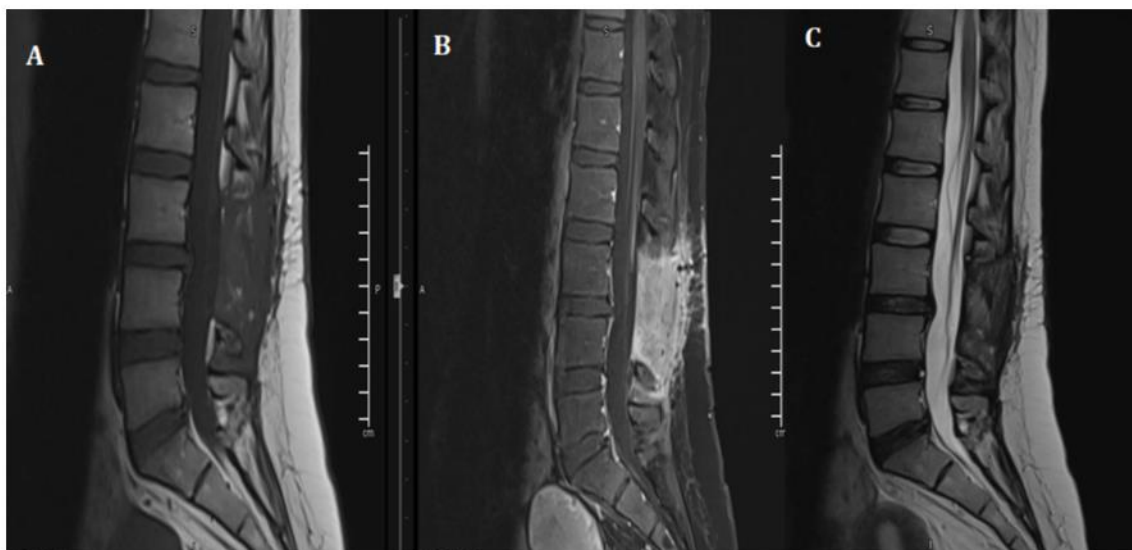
POST –OP follow up MRI shows total resection of the Lesion.
